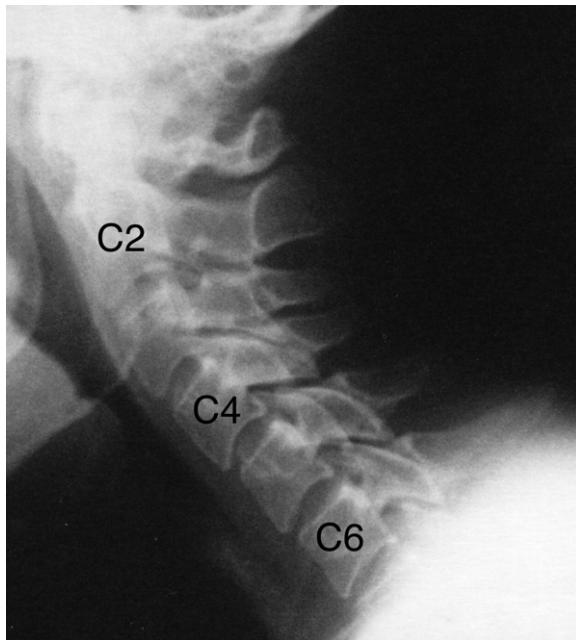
Cervical spine extension plain X-ray image. Note the marked limitation of range of movement with loss of normal cervical spine contour.
